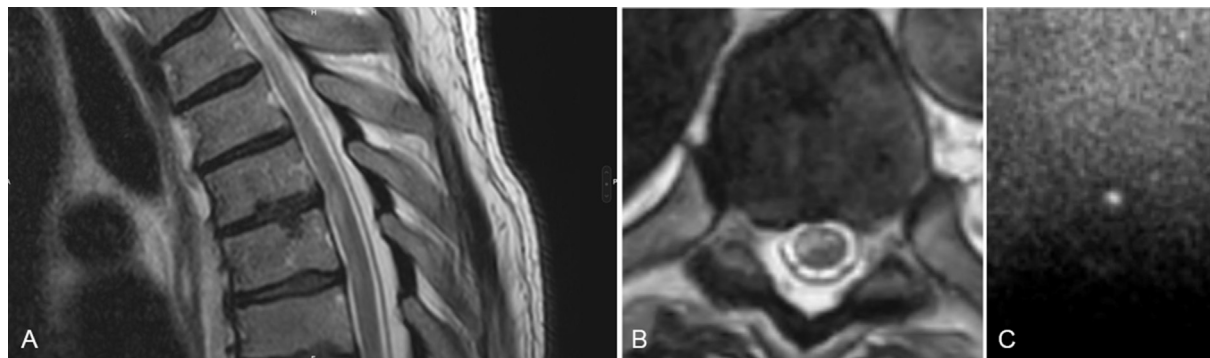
(A) On T2-weighted MRI images, appearance of a mild hyperintensity of the ventral spinal cord T6 with an adjacent intravertebral disc herniation (Schmorl node), (B) spinal hyperintensity on T2 axial image, (C) point-like hyperintensity on diffusion-weighted axial sequence.
